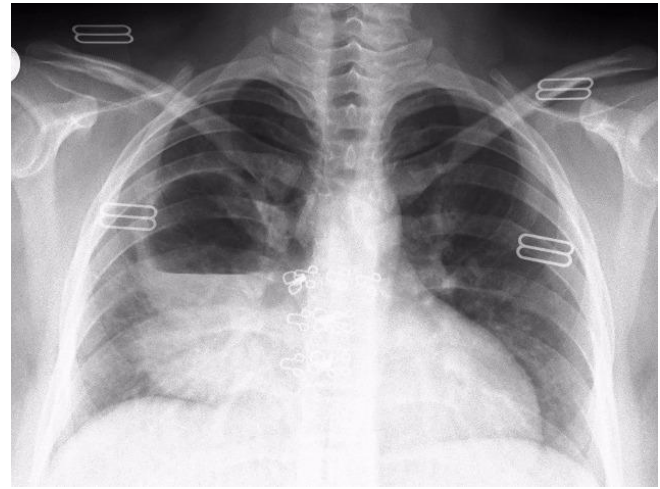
The chest radiograph on the 7th day of treatment
